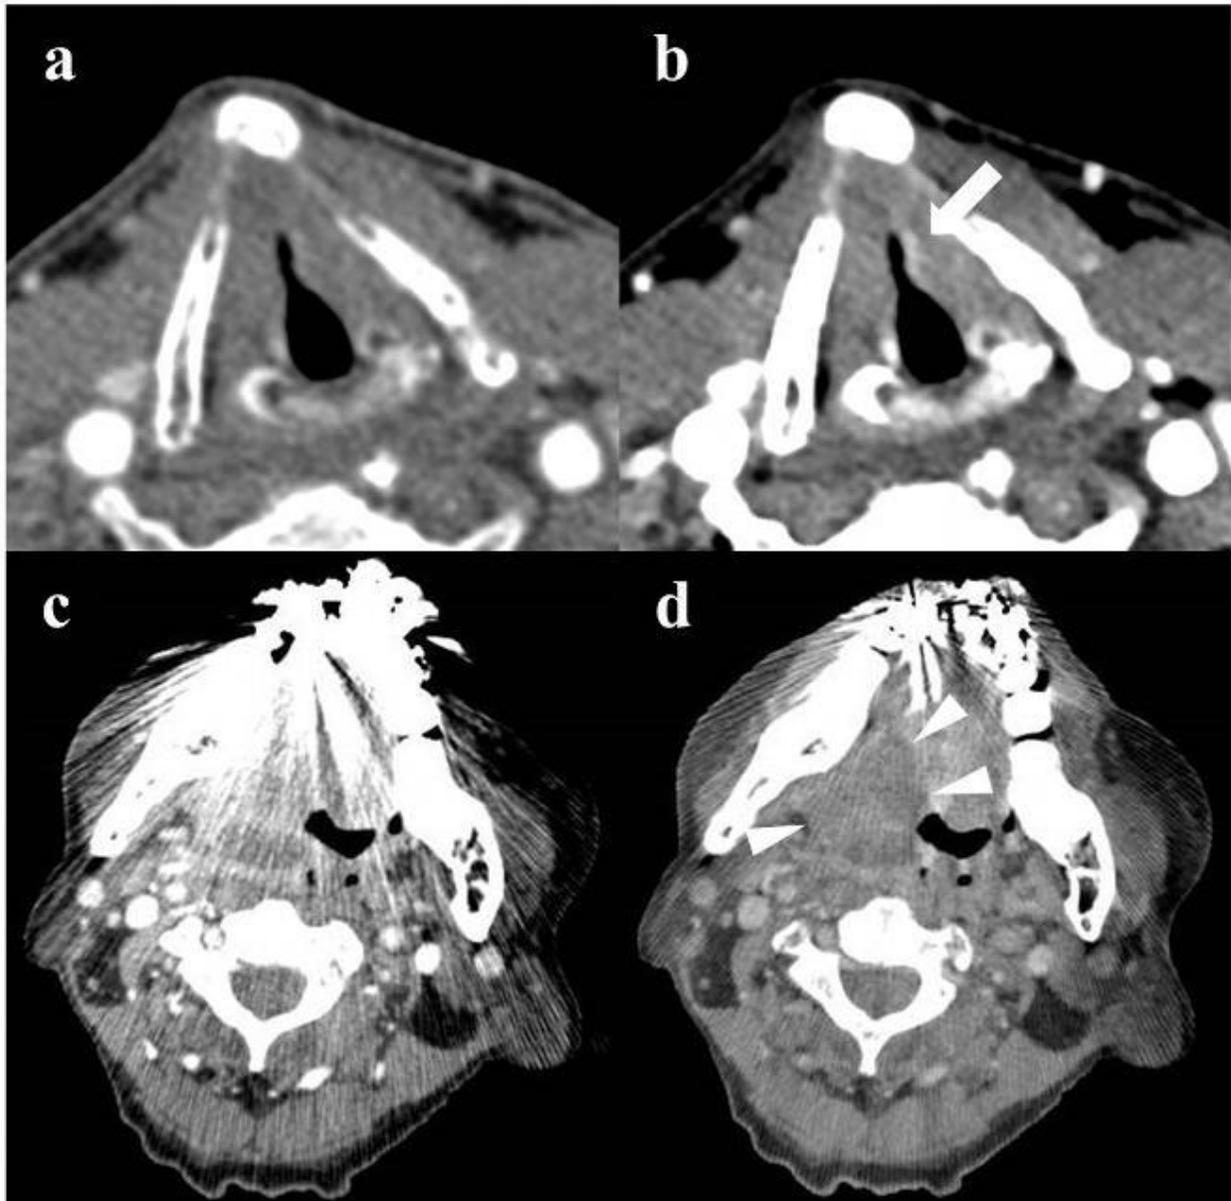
CT images of a 73-year-old male with glottic cancer (a,b) and a 67-year-old male with right tonsil cancer (c,d). The conspicuity of the tiny lesion (arrows) is greater on the 40 keV virtual monochromatic image (b) than on conventional 120 kVp image image (a). A tonsil tumor (arrow heads) is clearly detectable on the 120 keV virtual monochromatic image with metal artifact reduction technique (O-MAR) (d), whereas it is difficult to identify on conventional 120 kVp image image (c)
